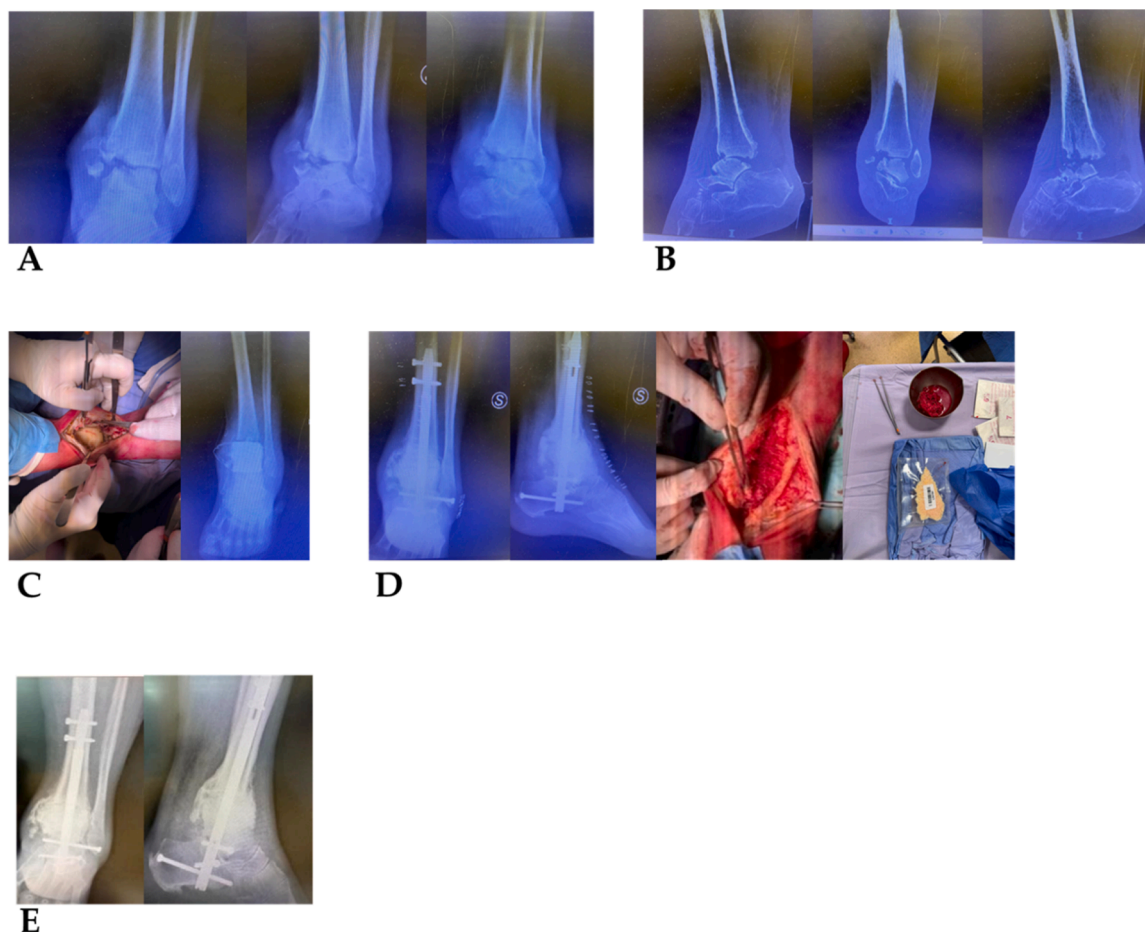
(A): X-ray of chronic ankle osteomyelitis with bone exposure and secerent malleolar fistula; (B): CT view; (C): intraoperative image and X-ray after pseudotumor resection and interposition of antibiotic cement; (D): surgical toilet and preparation of site heads for reduction and arthrodesis with intramedullary nail and RIA (reamer-irrigator-aspirator) and spongy bone of bank; (E): X-ray control at approximately 8 months.
